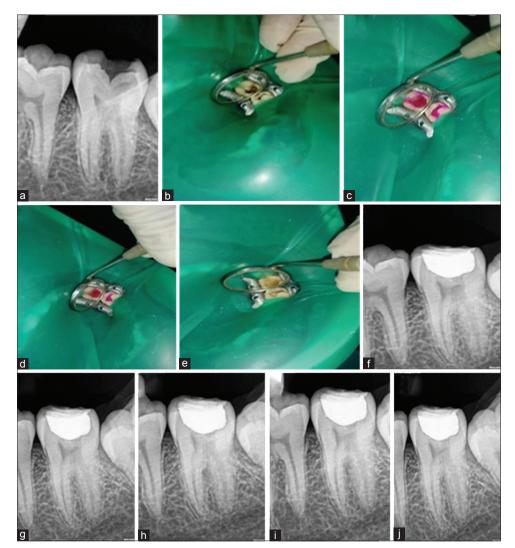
Complete caries removal case: Preoperative radiograph (a), preoperative photograph (b), photograph after apple of caries detector dye (c), photograph after wash of dye (d), photograph after complete removal of caries (e), radiograph at 1 month (f), radiograph at 3, 6, 12, and 18 months of follow-up (g-j)
